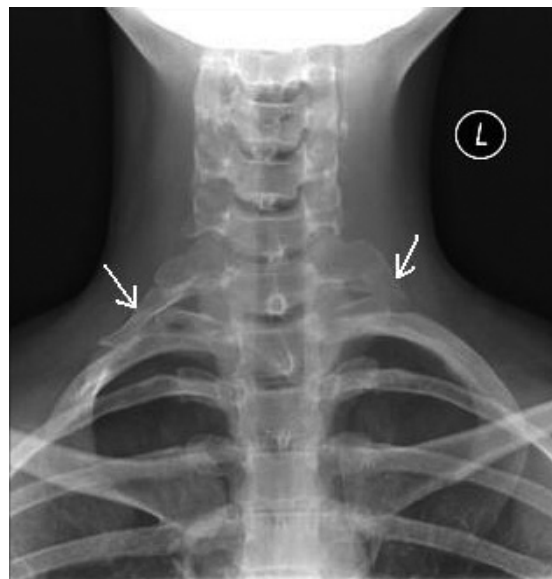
Frontal radiograph shows bilateral cervical ribs (arrows).
